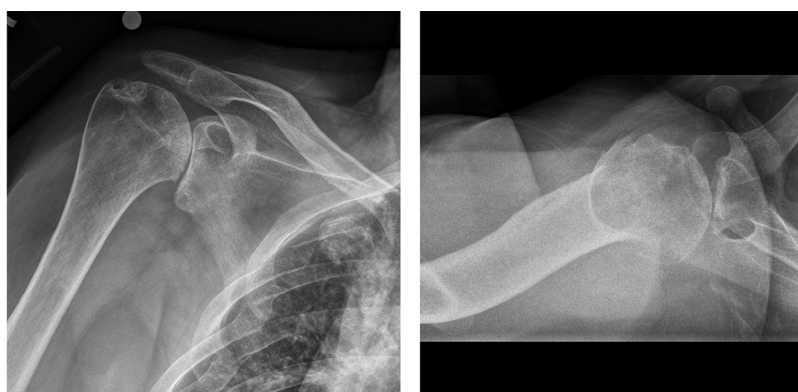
Anteroposterior and axillary radiographic views showing advanced arthritis with proximal migration of the humeral head associated with posterior subluxation in the setting of complete chronic deltoid paralysis.
